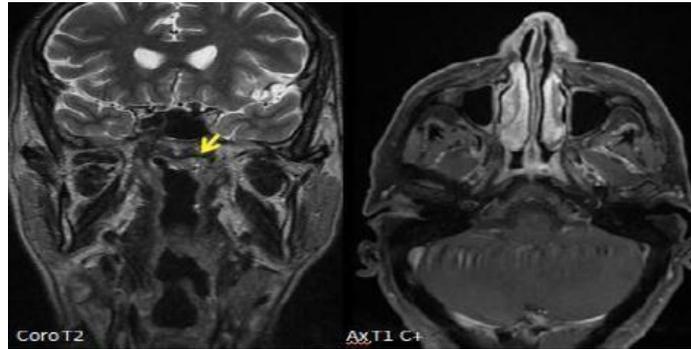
MRI of the cavum showing a well-limited thickening of the upper left lateral wall of the cavum with no locoregional extension classified as T1.^[50]
